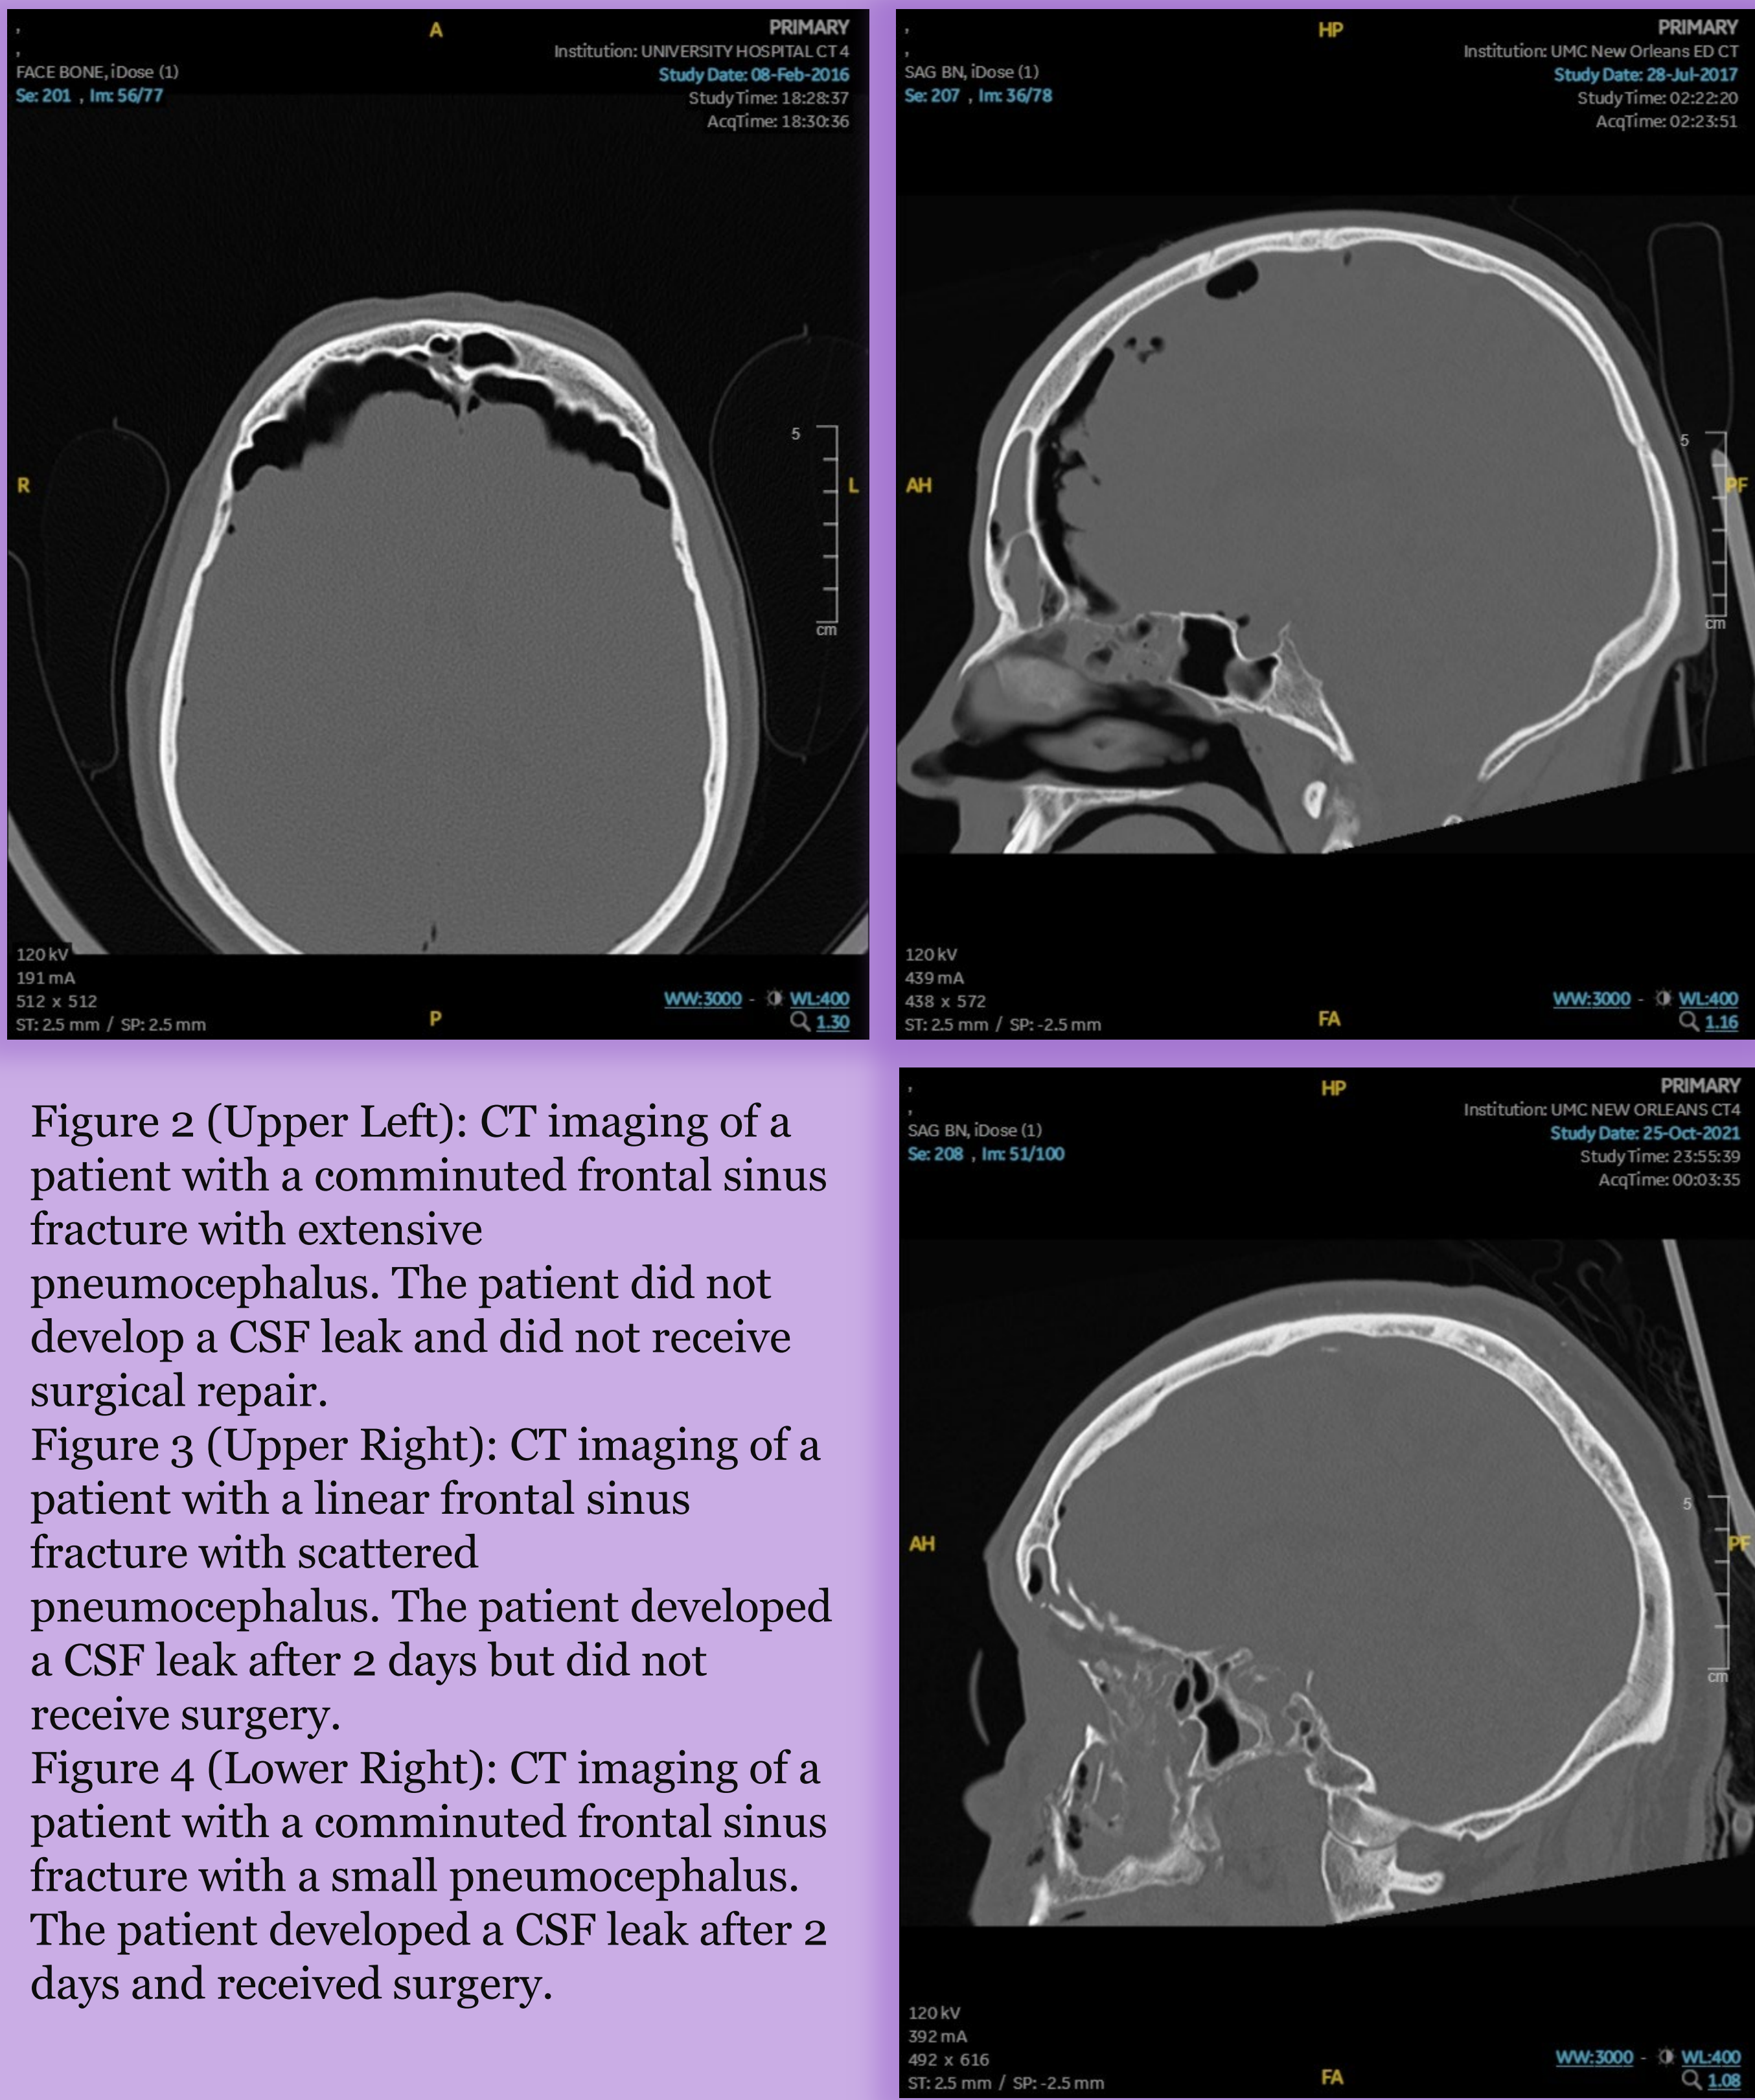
(Upper Left): CT imaging of a patient with a comminuted frontal sinus fracture with extensive pneumocephalus. The patient did not develop a CSF leak and did not receive surgical repair.
